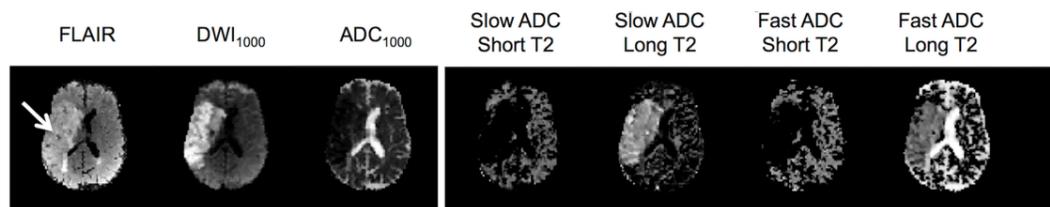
FLAIR, DWI-1000 (median signal at a b-value of 1000 s/mm², ADC: calculated using signal at b-values of 0 and 1000 s/mm²), and SF parameter maps for one of the patients used in this study. Arrow; infarcted area.
